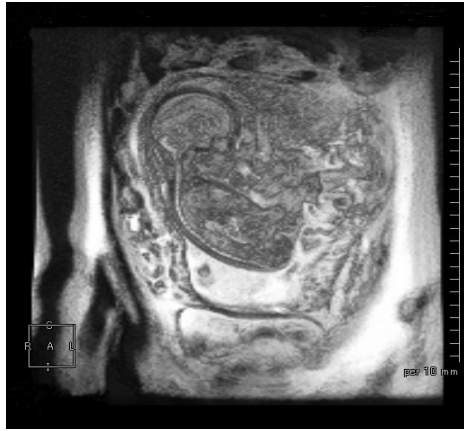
Example of MR image of pregnant woman in the 30th gestational week.
